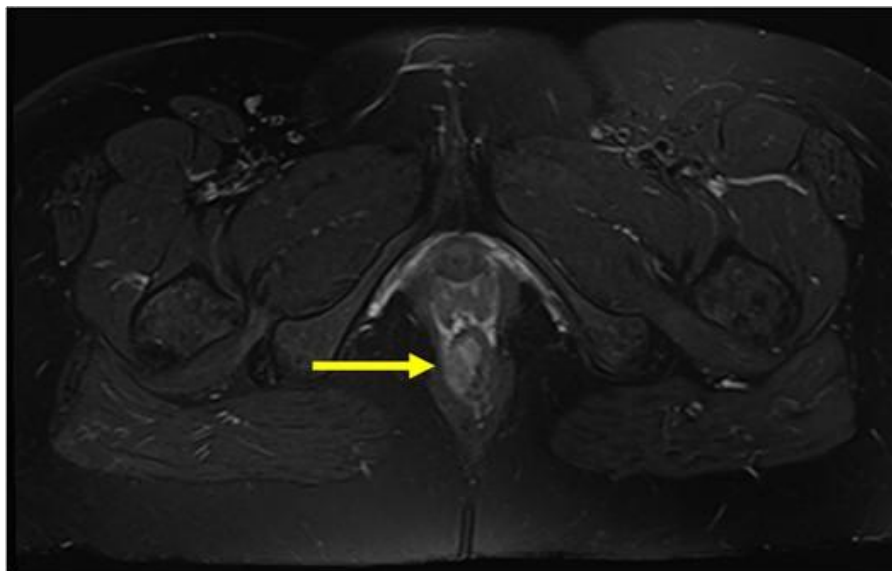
Magnetic Resonance Imaging (axial T2) of the pelvis before the treatment, yellow arrow indicating the tumor.
